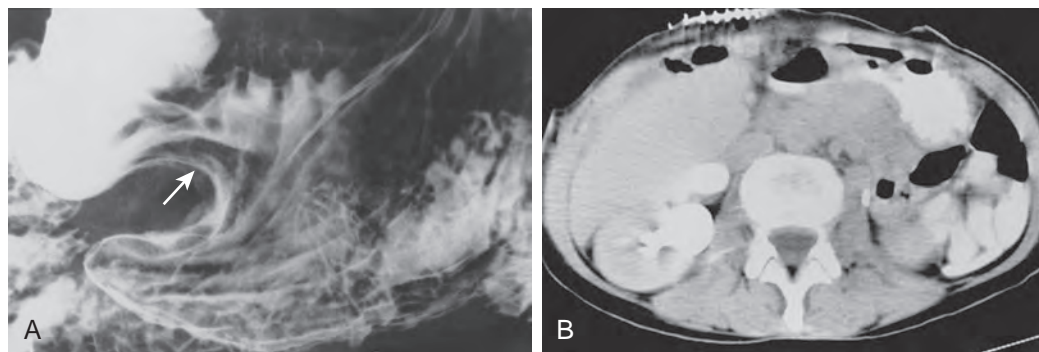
Gastric invasion by pancreatic carcinoma. A. Barium study shows a focal area of mass effect (arrow) on the greater curvature of the stomach. B. CT scan reveals an advanced pancreatic carcinoma invading the stomach.
